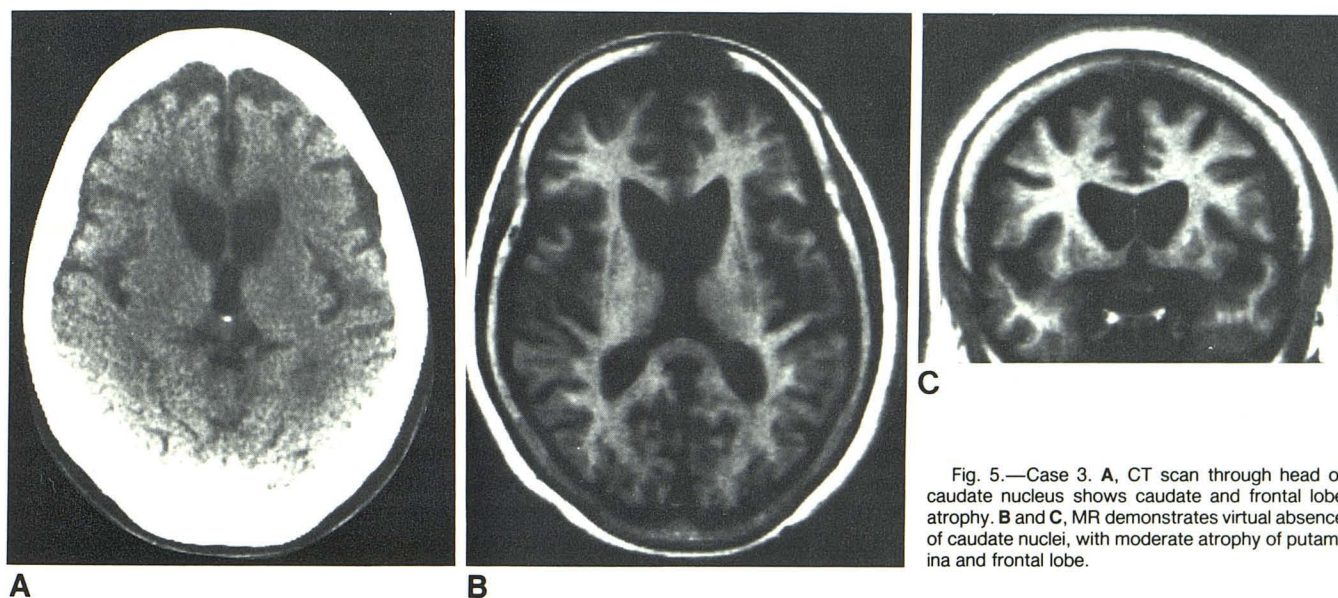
Case 3. A, CT scan through head of caudate nucleus shows caudate and frontal lobe atrophy. B and C, MR demonstrates virtual absence of caudate nuclei, with moderate atrophy of putamina and frontal lobe.
